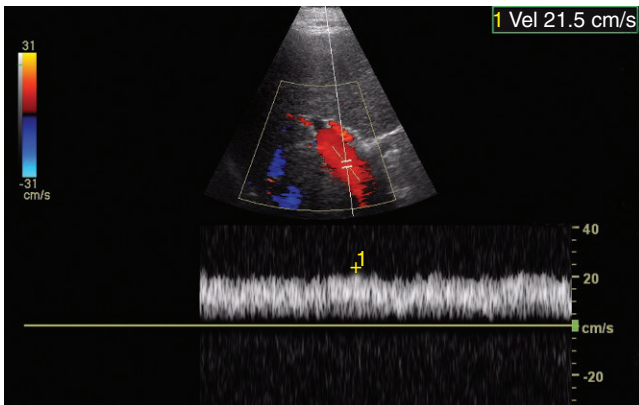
The duplex and color Doppler image shows a low velocity in the main portal vein of 22 cm/second, which is below the lower limits of normal (30 cm/second) and suggestive of a downstream stenosis in the stent graft.
